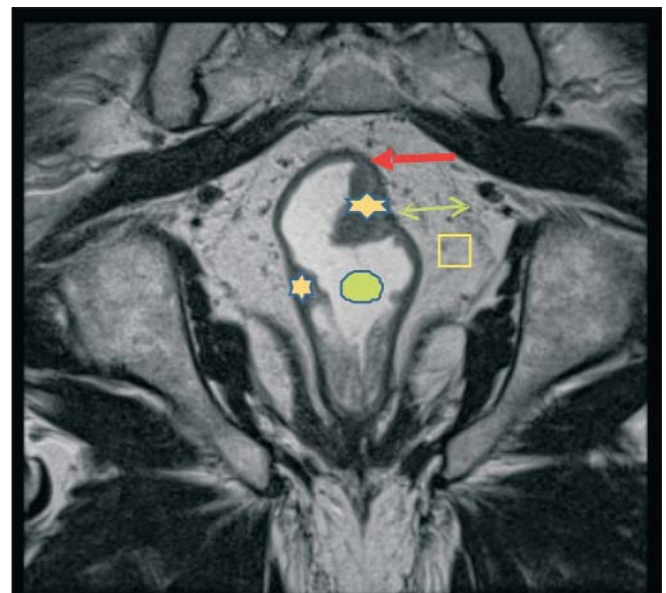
HD paracoronar MRI, stage T1: Rectal carcinoma has an average signal intensity (star), is well delimited after the water enema (white substance in the rectum - green circle). We notice that the tumour invades the submucosal layer without the infiltration of muscularis propria. The black strip (red arrow), namely muscularis propria is intact, the mesorectum is intact (square). Great distance to MRF (green arrow), there are no suspect lymph nodes in the mesorectum
